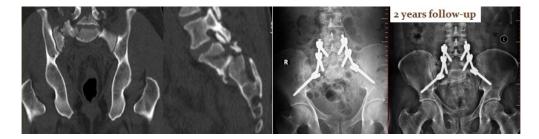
Pre-operative CT-scan and post-operative radiographs of a 16-year-old male showing Roy-Camille type-2 injury managed by lumbo-pelvic fixation
